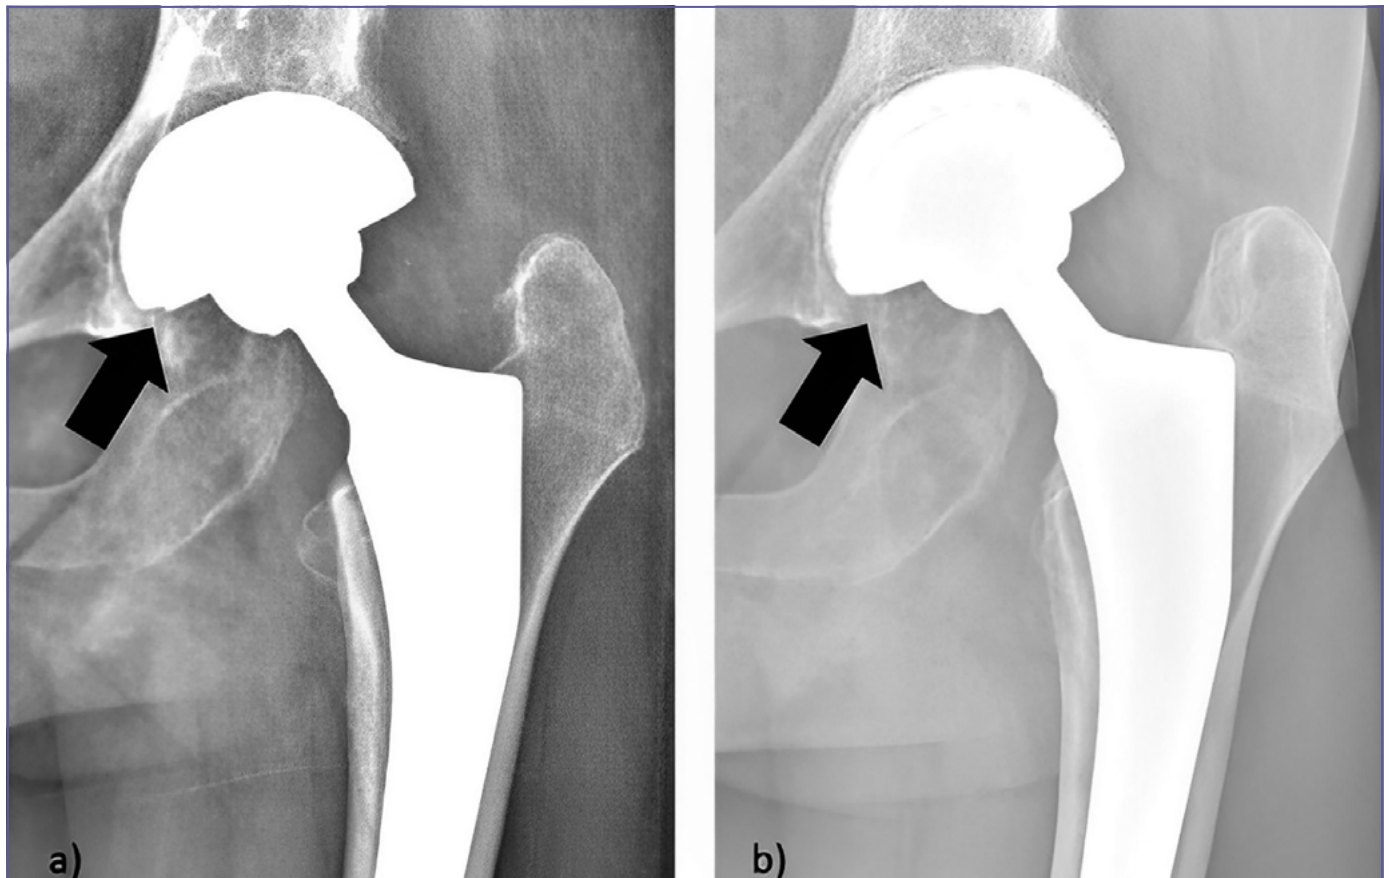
Seventy-five-year-old woman treated with total hip arthroplasty. A) at the post-operative X-ray is possible to see a radiological divergence of the shell line indicative of mispositioning (black arrow); B) at 1 year follow-up the divergence disappeared.
